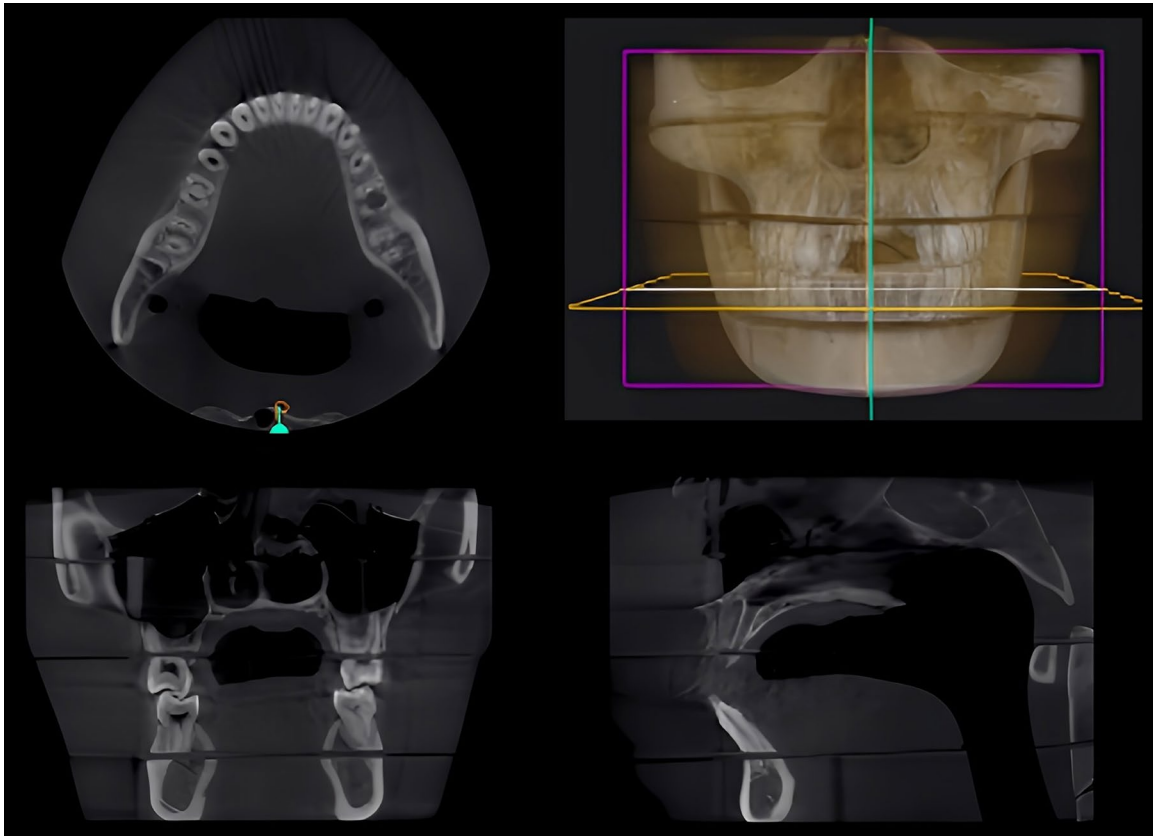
Axial, coronal, and sagittal cone-beam computed tomography reconstructions show the image quality achieved with protocol 5 (3 mA; 99 kVp; 450 projection images), which was identified as the optimized protocol.
